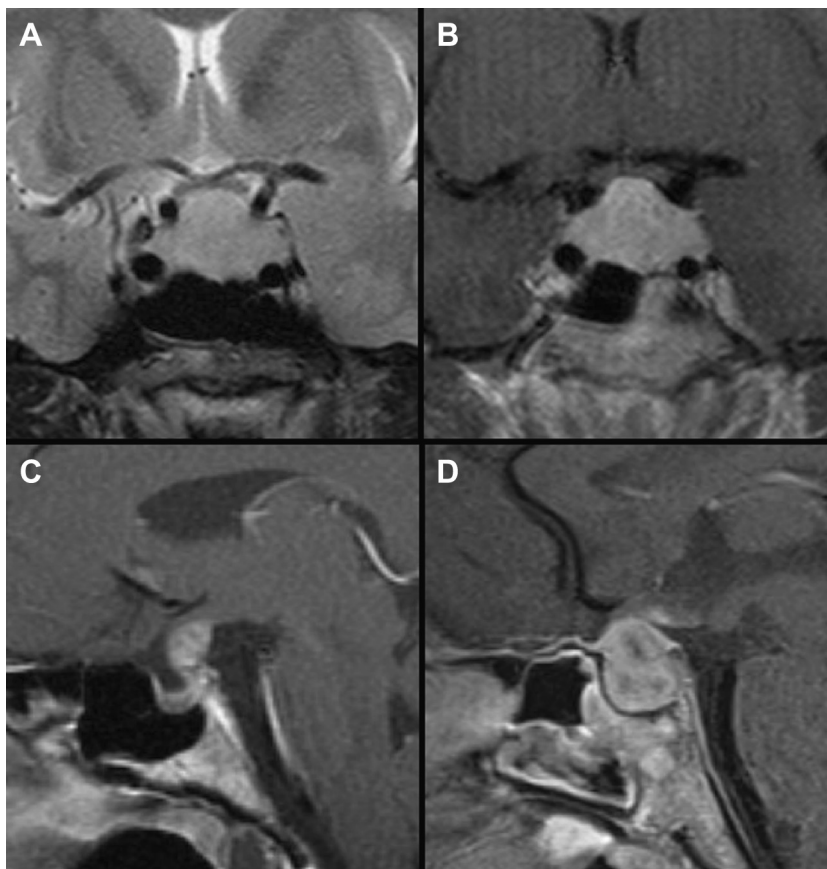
Pituitary hyperplasia (A, B) and lymphocytic hypophysitis (C, D). Both T2-weighted (A) and gadolinium-enhanced T1-weighted (B) images show enlargement the pituitary gland with uniform T2 signal intensity and enhancement, without sellar enlargement, in a 28-year-old woman presenting with hyperprolactinemia and hypothyroidism. (C, D) Two cases of lymphocytic hypophysitis, one with infundibular thickening (C) and the other showing heterogeneous enhancement within an enlarged pituitary gland (D). In D, note subtle thickening of the sellar diaphragm with adjacent “tails” of inflammatory dural enhancement anterior and posterior to the gland along the planum sphenoidale and dorsum sellae.
